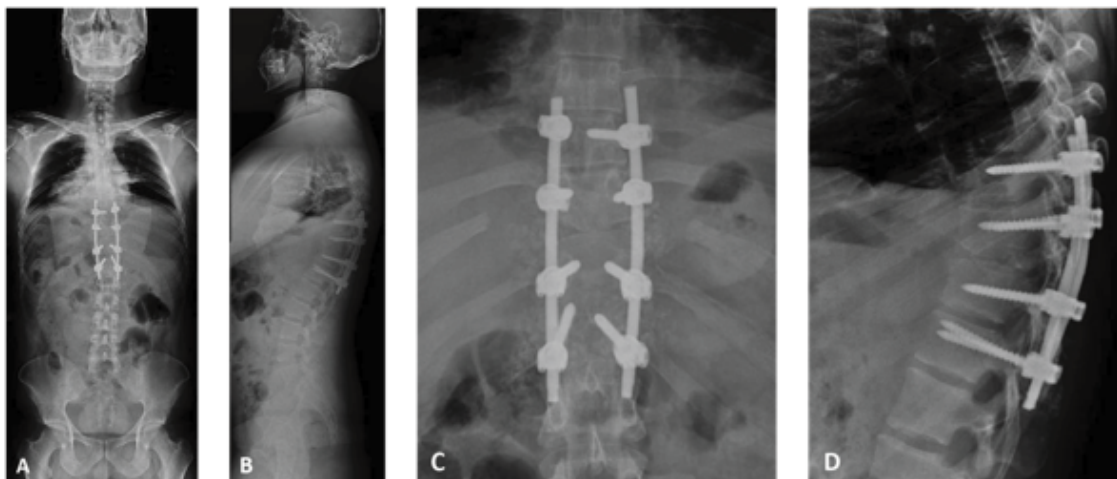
Postoperative total anterior-posterior and lateral X-rays (A and B) and focused thoracolumbar spine (C and D).
